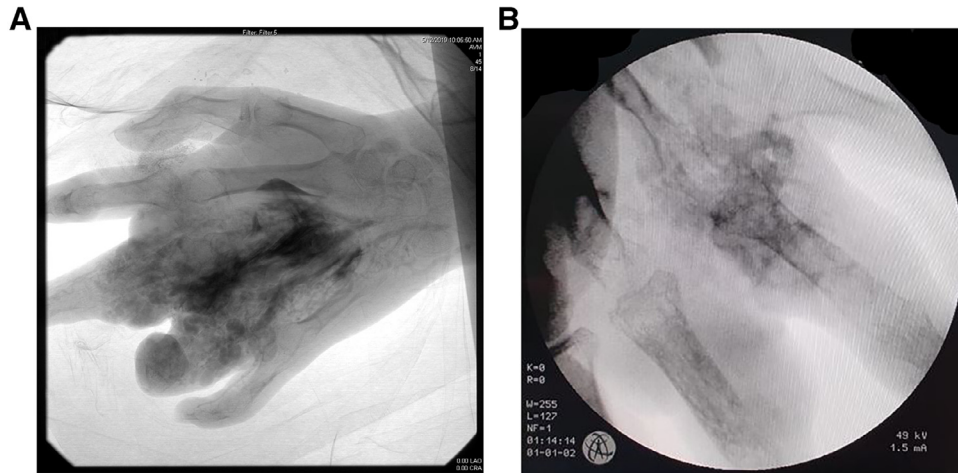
Angiogram after first and second sclerotherapy. A: First direct puncture sclerotherapy under DSA using absolute ethanol was targeted on the nidus. Post sclerotherapy angiogram shows adequate devascularization. B: Second sclerotherapy a month after the first sclerotherapy, guided by ultrasound and fluoroscopy, targeted the nidus around third and fourth digits until devascularization was visualized.
